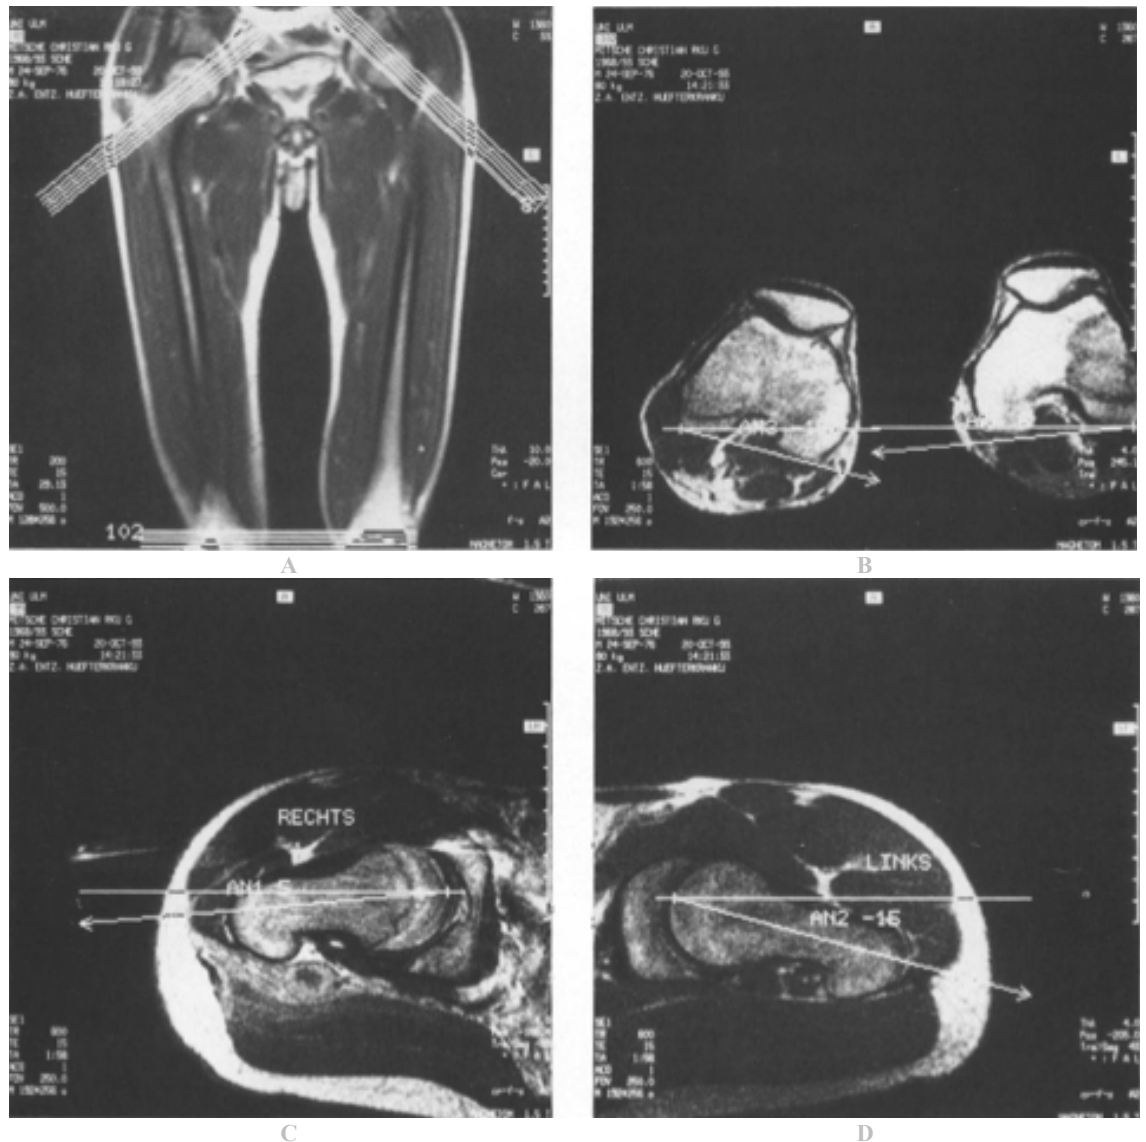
MRI determination of femoral torsion. A; proximal axis – femoral neck axis, B; distal axis – posterior condyles, C; image of the proximal axis of the right hip viewed from the top, D; image of the proximal axis of the left hip viewed from the top (Guenter et al, 1995)⁵⁴
